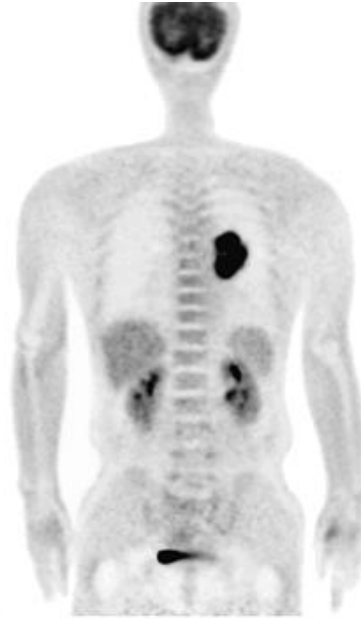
Patient with lung cancer imaged with FDG-PET. Image is reproduced from (Kaira et al., 2009). Dark colours indicate high uptake, while light colours indicate low uptake. The dark spot in the left lung is the lung tumour.
